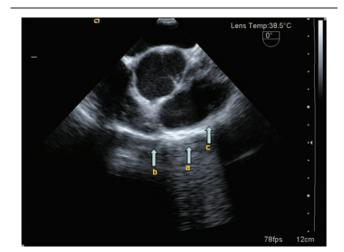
Ultrasonic images after surgery. (a) Bar. (b) Sternum. (c) Pericardium.
